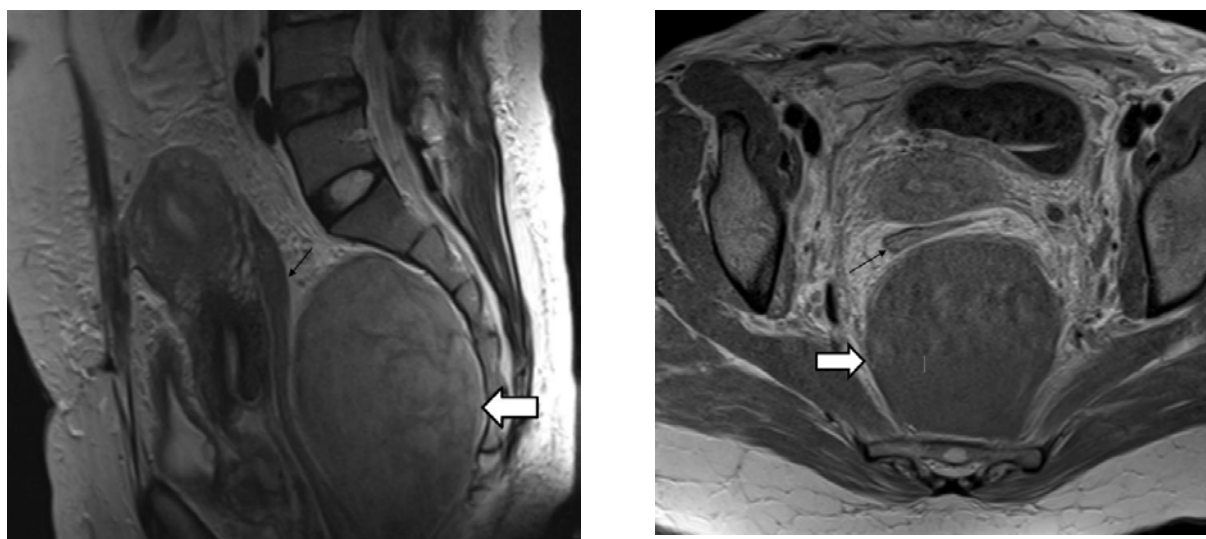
Sagittal T2W (A) and axial post-contrast T1W (B) MRI images of pelvis show a non-enhancing pre-sacral mass (A arrow) posterior to the rectum (B arrow), consistent with hematoma
